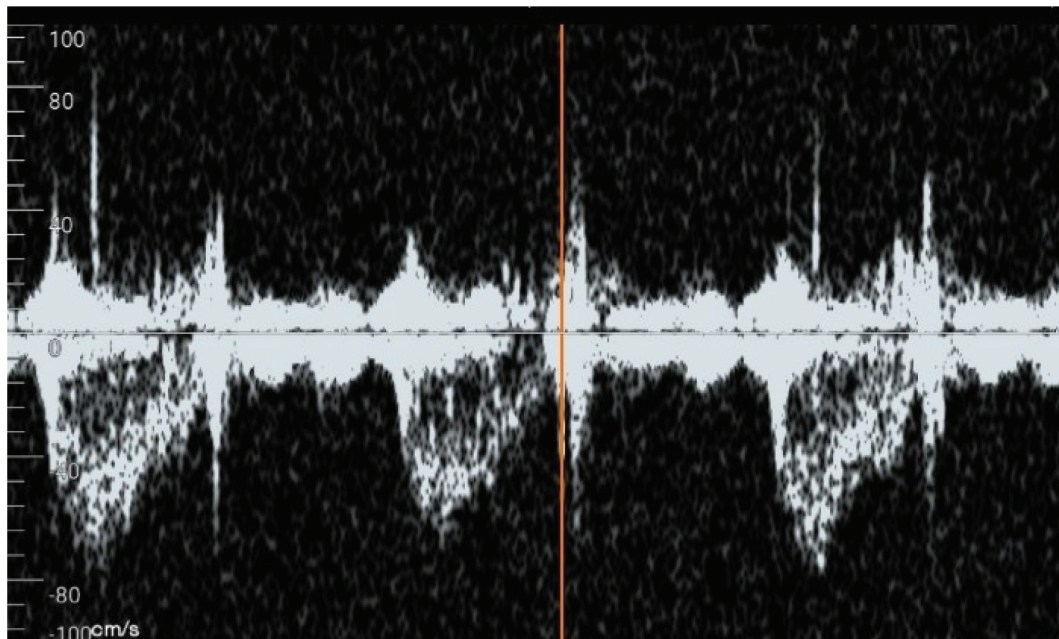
Right ventricular outflow tract Doppler pre-lytic therapy, showing a "spike and ball" pattern with a low pulmonary acceleration time (PAAT) of 80 ms.
